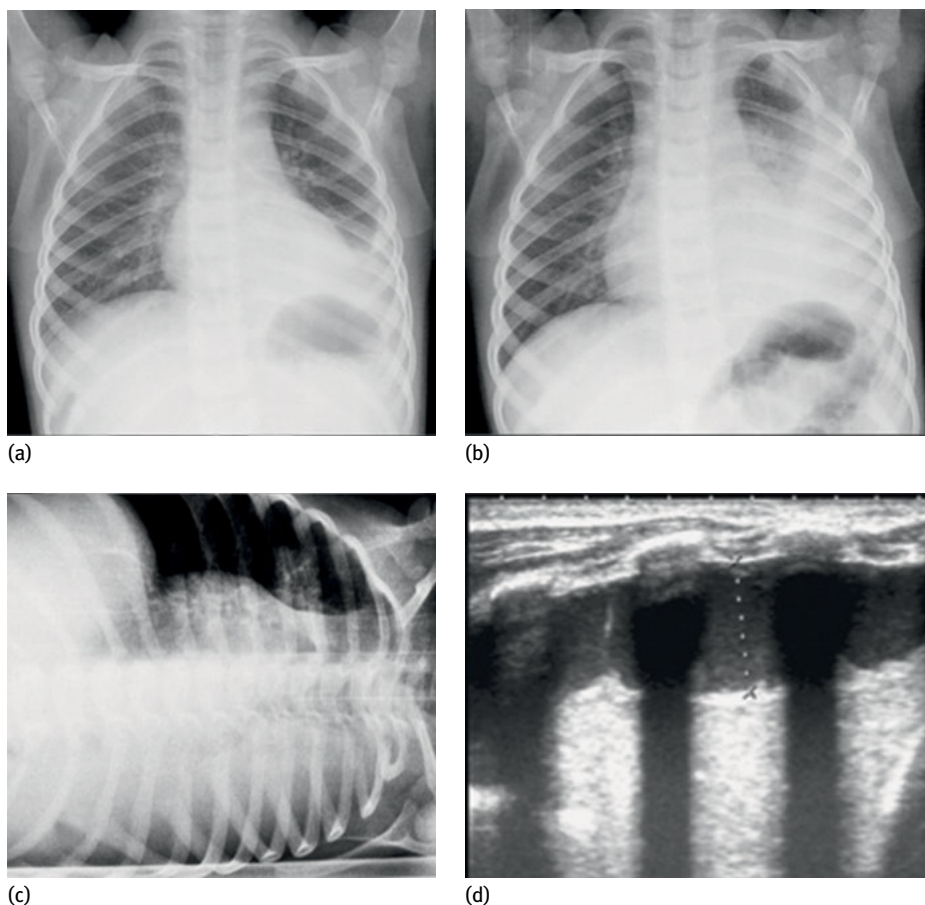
Plain X-ray of the thorax showing basal pneumonia with parapneumonic Stage I effusion on the left in a 3-year old boy. (a) at presentation, (b) 48 hours later. The amount of fluid increased greatly, as better shown by the film taken lying on the left side (c). Intercoastal ultrasonography or US (d) shows a fluid rim of more than 10 mm.
